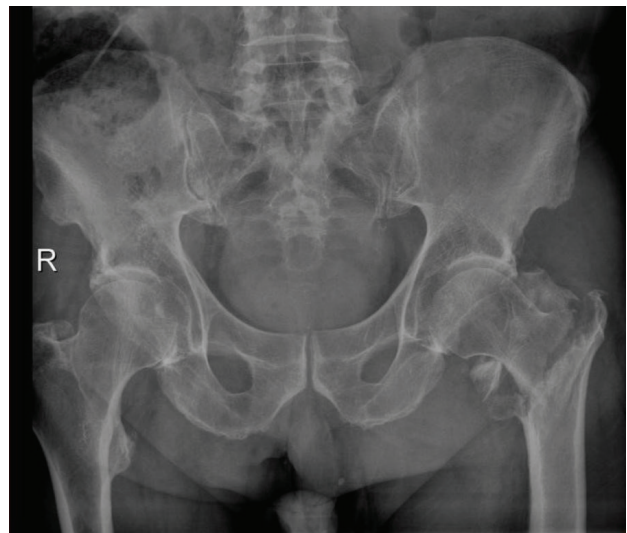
Preoperative X-ray showing intertrochanteric fracture
